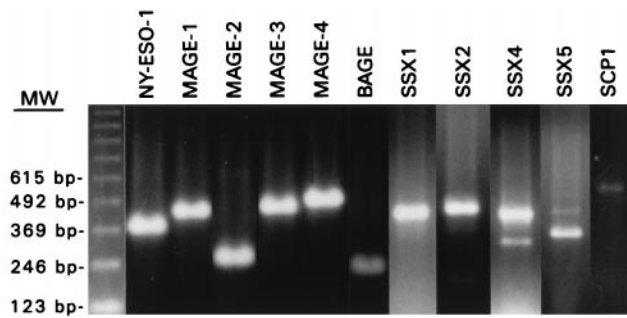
RT-PCR analysis of CT antigen expression in the established melanoma cell line SK-MEL-37. SK-MEL-37 showed expression of all CT products tested, i.e., NY-ESO-1, MAGE1, MAGE-2, MAGE-3, MAGE-4, BAGE, SSX1, SSX2, SSX4, SSX5, and SCP1. The minor band of lower molecular mass in SSX4 represents an alternate-spliced variant (18).
